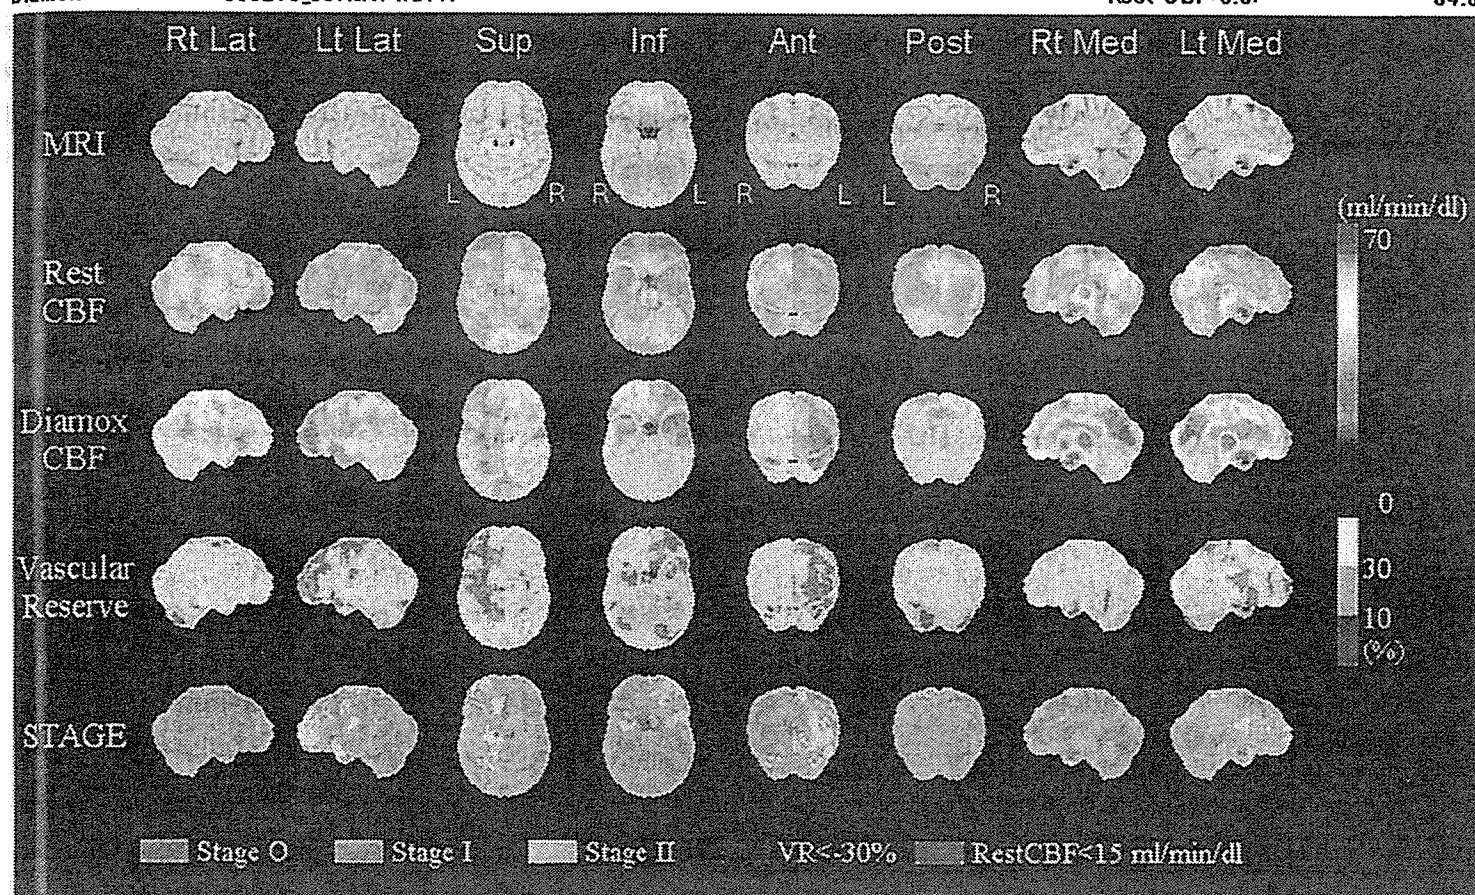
図 4-9 の症例での術後脳血流 SPECT の SEE 解析
